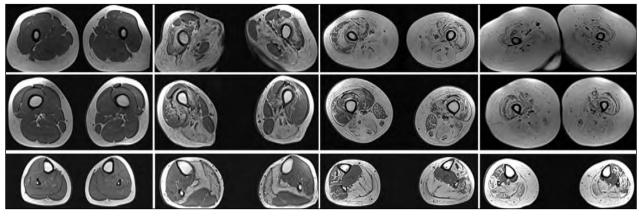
Muscle MRI findings in patients with calpainopathy.
